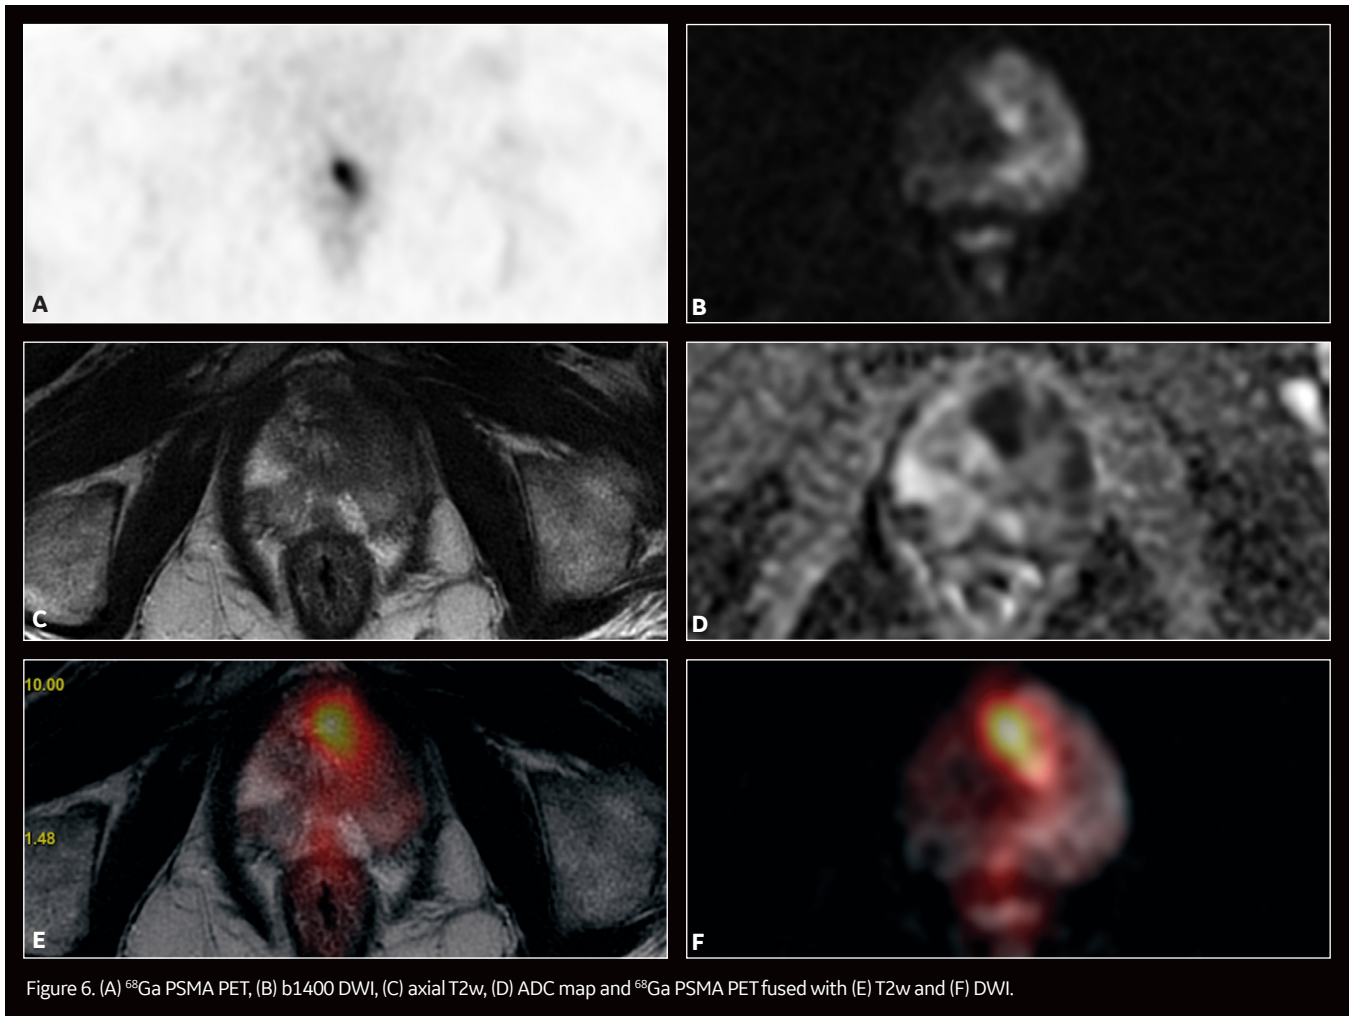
(A) ⁶⁸Ga PSMA PET, (B) b1400 DWI, (C) axial T2w, (D) ADC map and ⁶⁸Ga PSMA PET fused with (E) T2w and (F) DWI.
